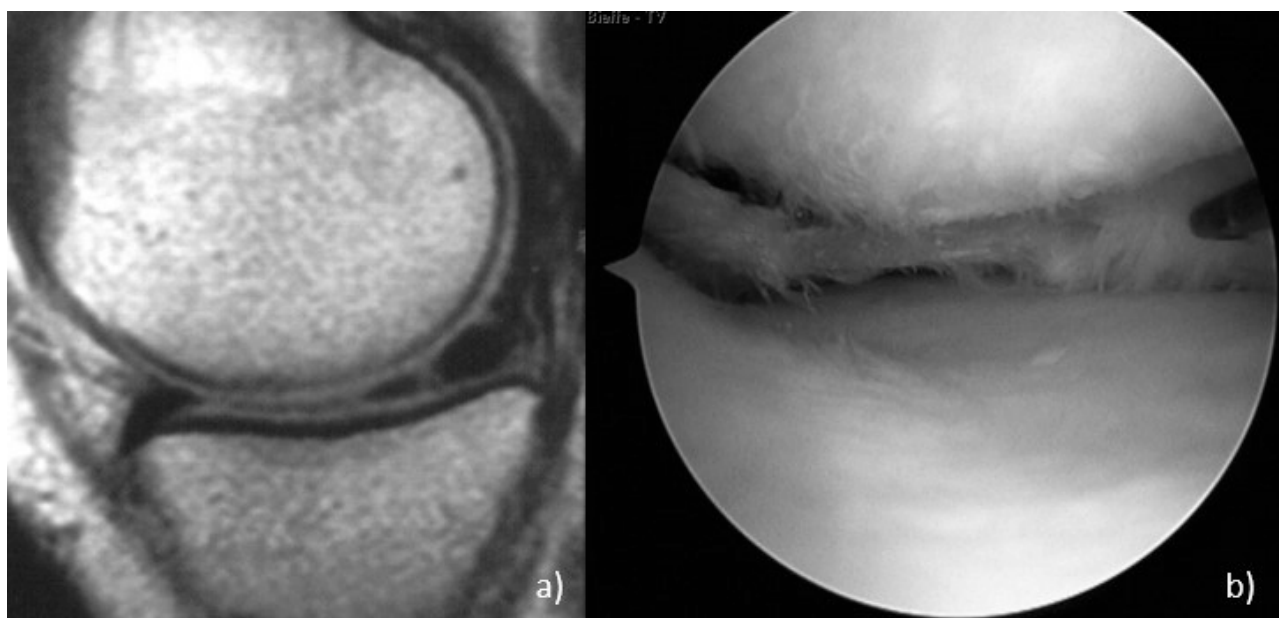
Sagittal (a) MRI findings of longitudinal degenerative lesion of the posterior horn of the medial meniscus, and corresponding arthroscopic findings in (b).
